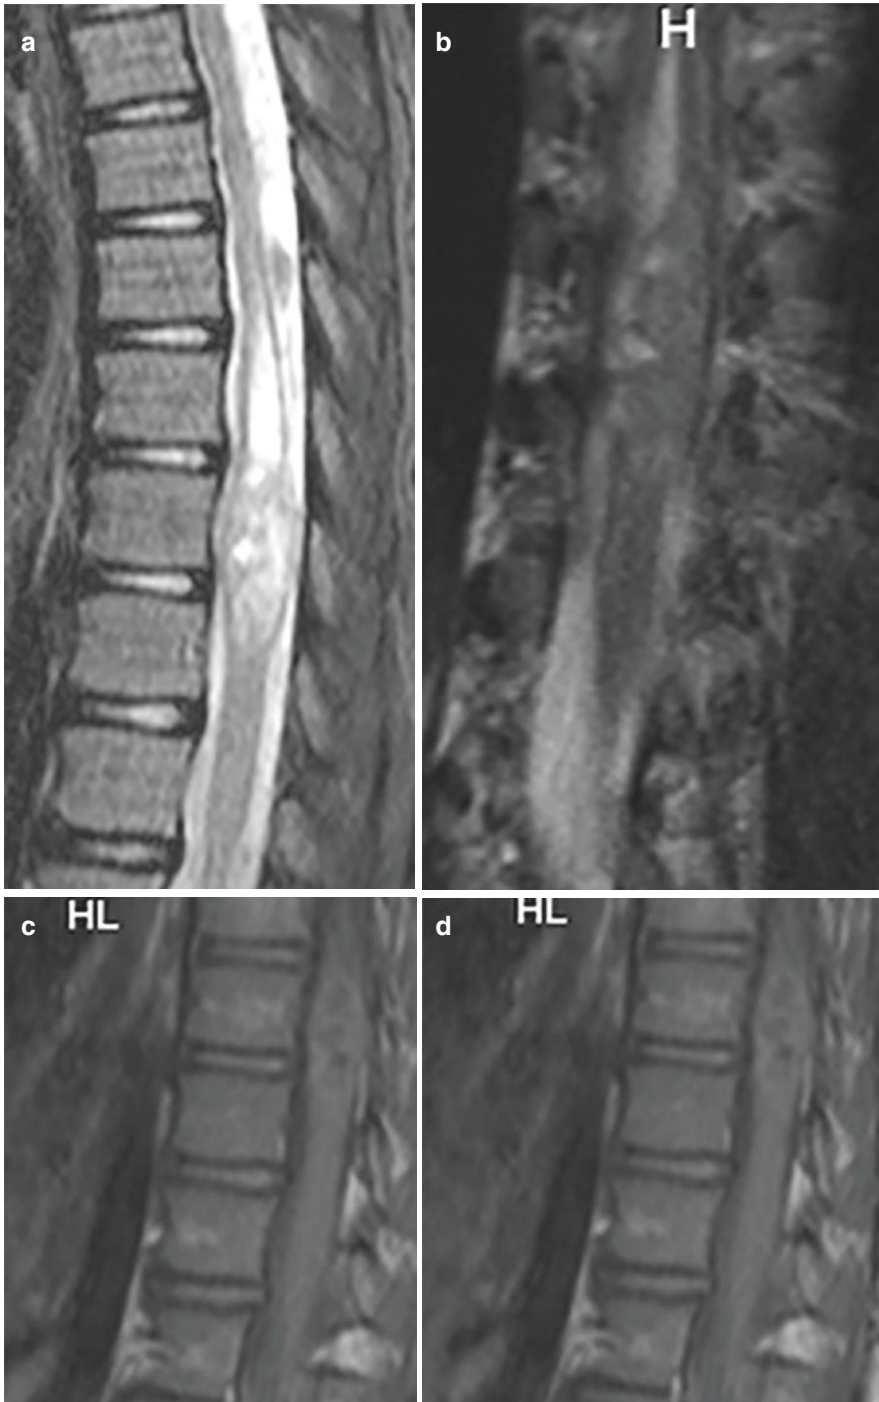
Ganglioglioma. Sagittal and coronal STIR (a, b), T1-weighted (c), and contrast enhanced T1-weighted (d) images demonstrating well-defined poorly enhancing mass with areas of cyst degeneration
